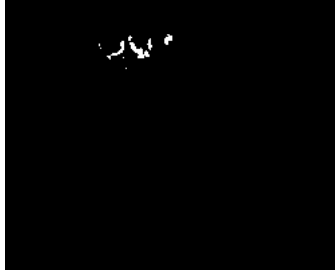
Binarized Power Doppler image after getting rid of outliers.
